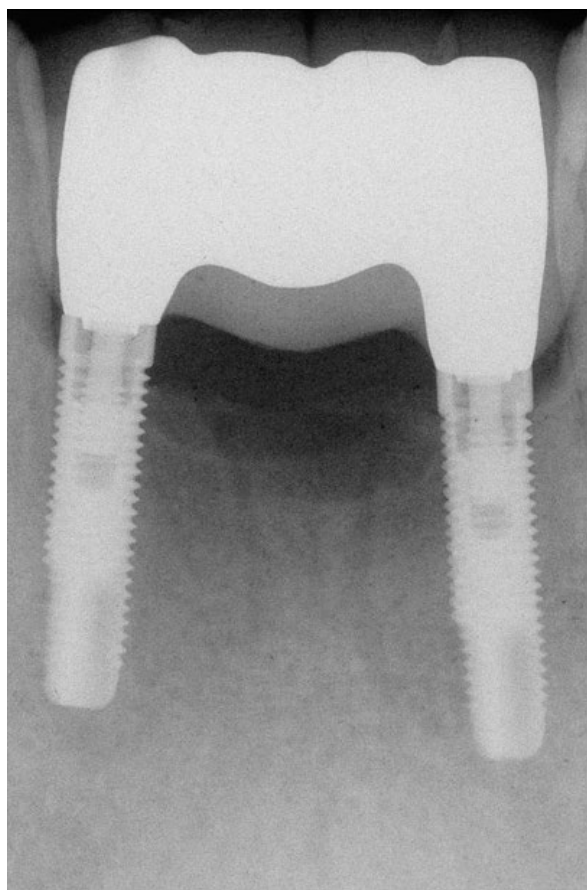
(E) Radiographic evaluation of restoration fit with implant platforms.
